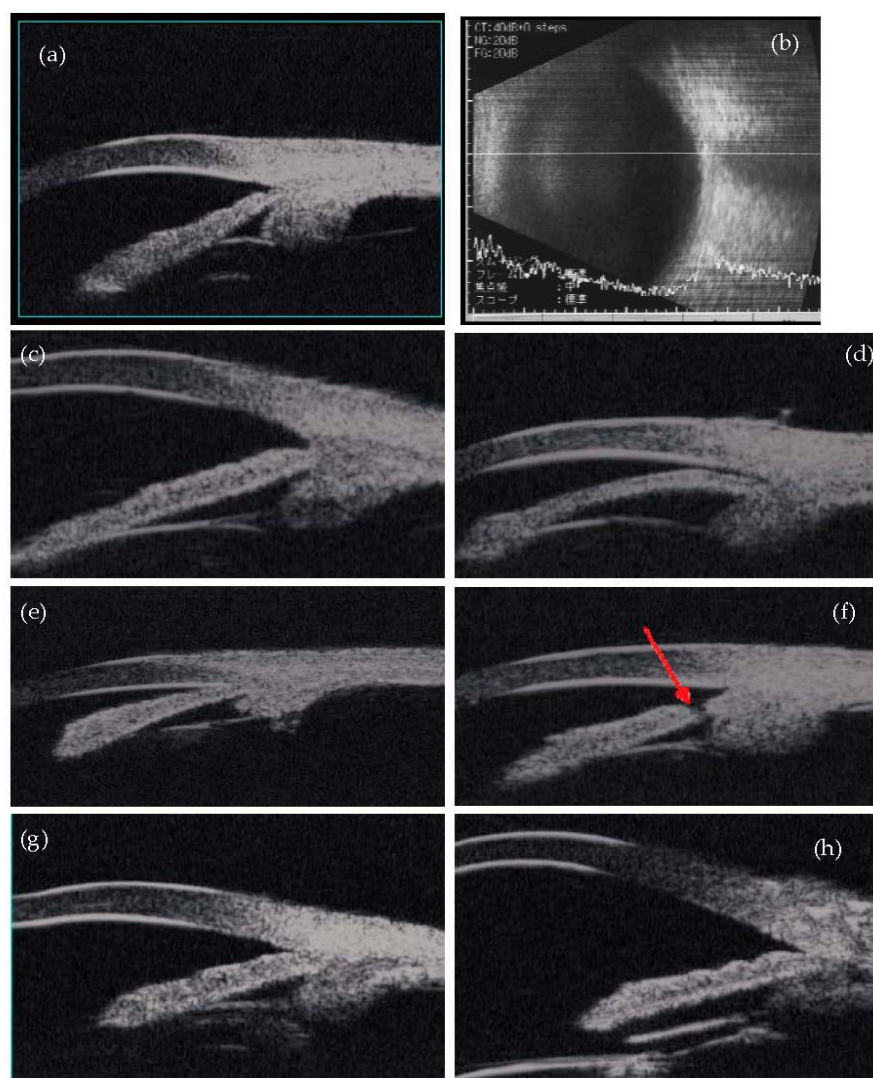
(a) UBM image of the normal anterior segment. This scan demonstrates all anterior segment structures, including anterior lens surface, iris, and ciliary body. In UBM, frequencies of 35-50 MHz and above provide over a three-fold improvement in resolution compared with conventional ophthalmic ultrasound systems (b). (b). Conventional B-mode ultrasound image of the posterior segment. (c) and (d). UBM image of the normal (c) and the PAC anterior segment (d). Note the shallow anterior chamber depth of the PAC compared with the normal. (e) and (f). UBM image of the anterior segment of the PACG patient before (e) and after laser iridotomy (f). Note the increase of anterior chamber depth after laser iridotomy (LI). Arrow indicates the portion of the LI. (g) and (h). UBM image of the anterior segment of the PACG patient before (g) and after cataract surgery (phacoemulsification and intraocular lens implantation) (h). Note the increase of anterior chamber depth after cataract surgery.
